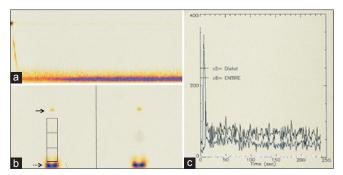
Esophageal transit scintigraphy done with semisolid bolus in sitting position in 25-year-old woman showing condensed dynamic images (a), whole and segmental esophageal region of interest showing transit of semisolid bolus (b) (solid arrow shows tracer activity in the mouth; broken arrow shows tracer activity in the proximal stomach), whole and segmental esophageal time activity curves (c)
